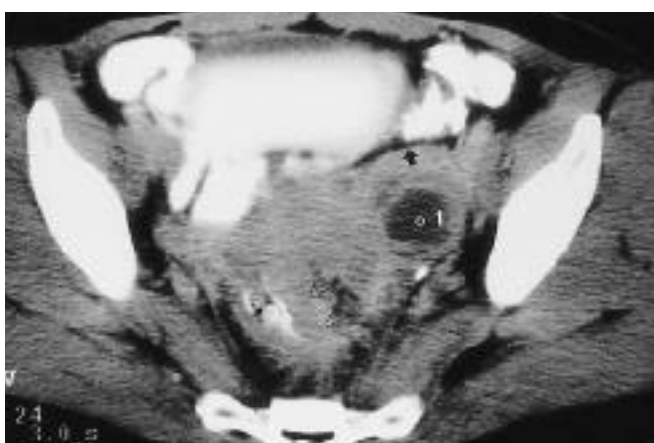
A 50-year-old female with tuboovarian abscess. Postcontrast CT scan shows multiseptated, thick-walled masses at the both adnexa causing anterior displacement of the both mesosalpinges (arrow). B= bladder
